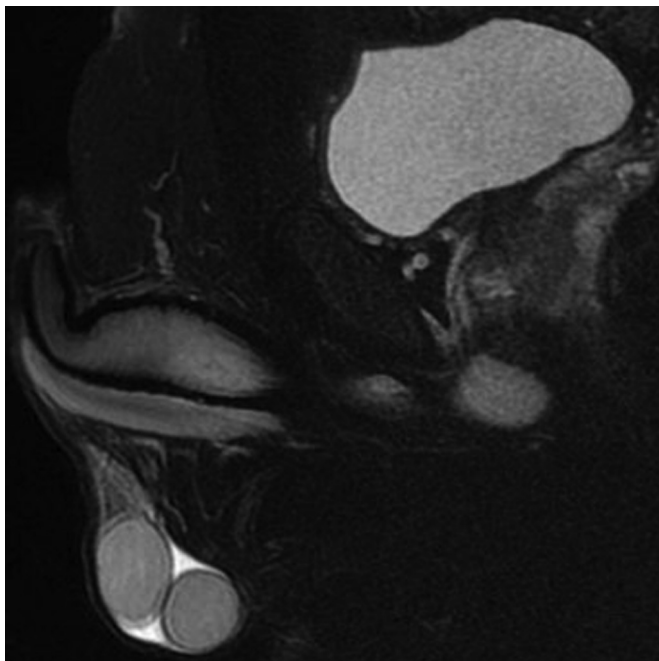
Sagittal MRI T2 FRFSE with fat saturation showing supernumerary testicle in the left side inferiorly, having the same MR imaging characteristics as the normal testes.
